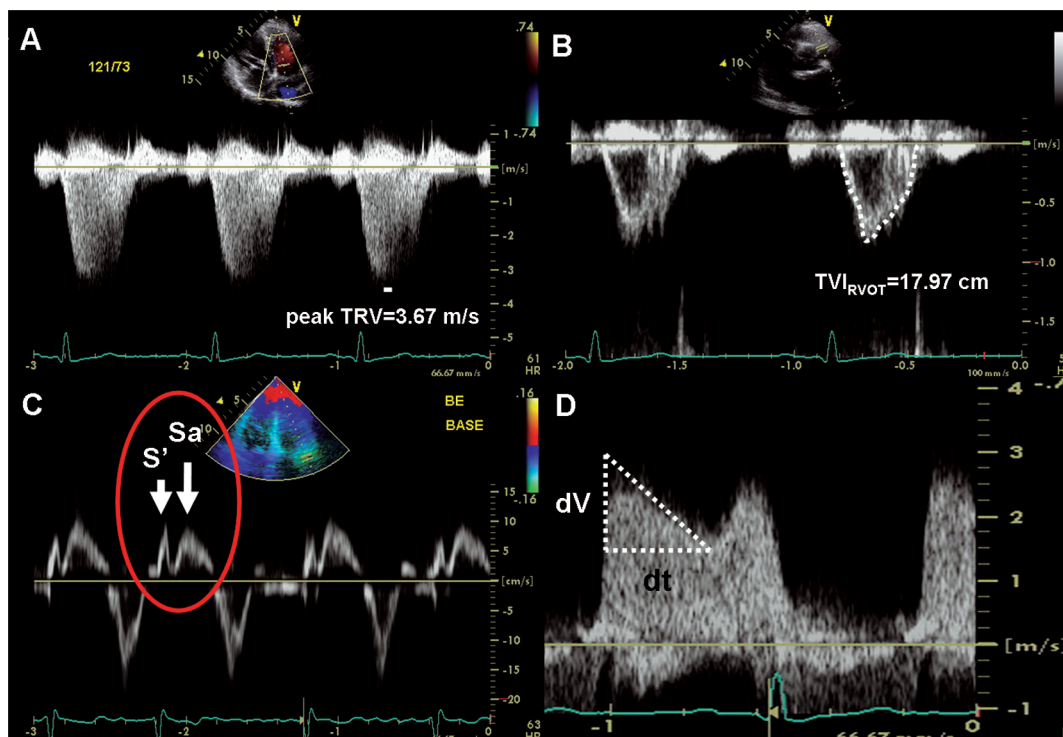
Doppler images show tricuspid regurgitant velocity (TRV) (A) and the time-velocity integral at the right ventricular outflow tract (TVI_{RVOT}) (B) at resting stage. The echo-Doppler-derived pulmonary vascular resistance, calculated as $10 \times (\text{peak TRV} / \text{TVI}_{\text{RVOT}}) + 0.16$, is 2.2 Wood unit. Tricuspid annular tissue Doppler image (C) shows peak systolic annular velocity (Sa), first positive reflection of annular velocity, indicates isovolumic contractional velocity (S'). Net-atrioventricular compliance can be calculated from the deceleration rate (dV/dt) (D) of the mitral velocity profile (E-wave downslope) and effective mitral orifice area determined equation continuity.
